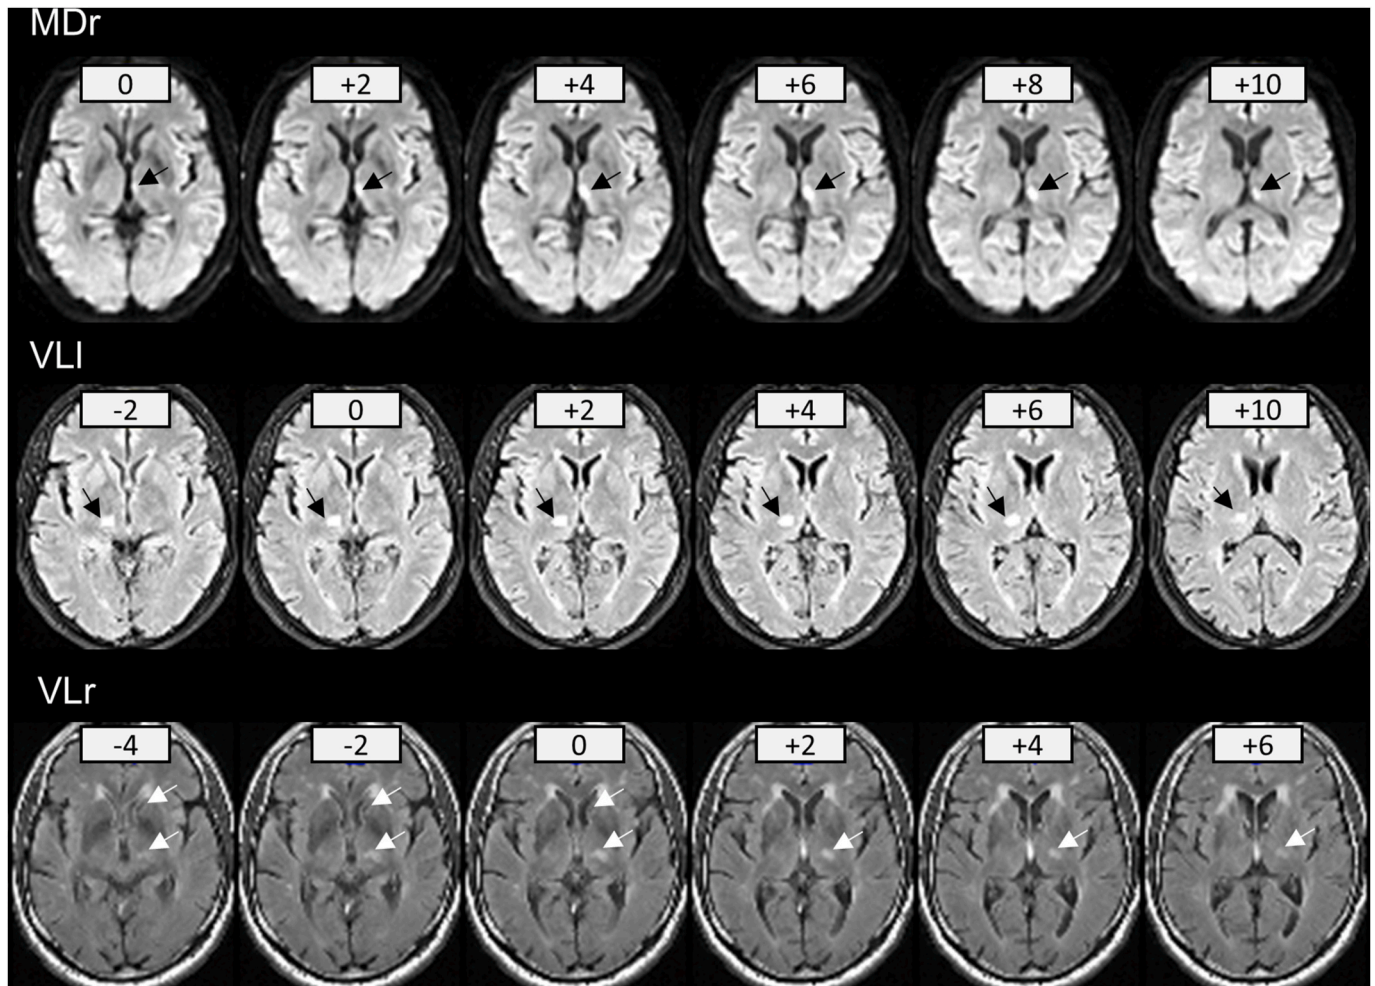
Individual magnetic resonance images of lesion locations. For each patient (rMD, lVL, rVL), normalized axial sections (z-coordinate levels indicated in mm) displaying the full extent of the lesion are presented. For each participant, we chose images from that one of the acquired sequences (see Table S1 for a list of the images per patient), in which the lesion was most clearly visible. White and black arrows indicate lesion locations.
